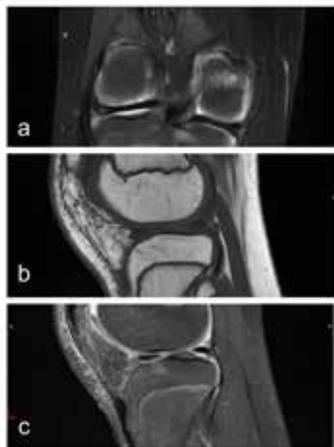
Postoperative MRI of the right knee, 18 months after the fixation of the L.F.C, OCD lesion with Chondral Darts. Complete healing of the OCD lesion.
